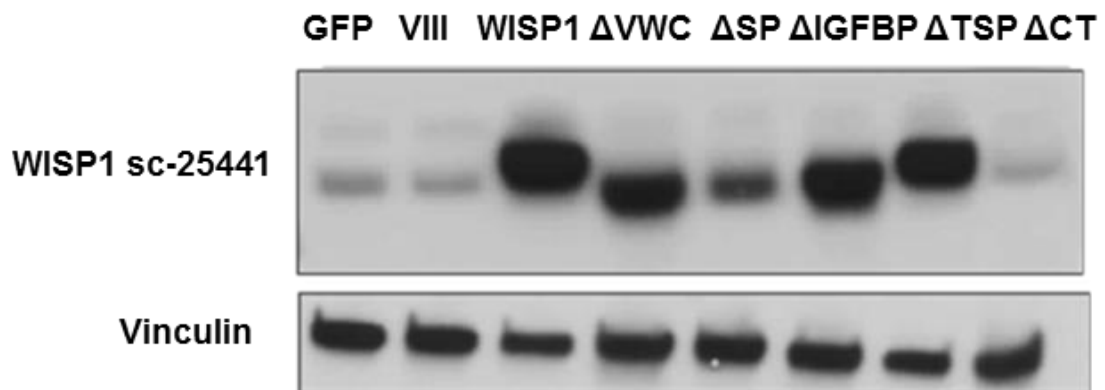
Immunoblots from lysates of U87MG cells expressing each truncated form and the controls (GFP, EGFRvIII, WISP1). Two different antibodies were used since the Δ CT WISP1 is not picked up by the antibody that recognizes an epitope from amino acids 311-367 (sc-25441) while the Δ VWC WISP1 is not picked up by the antibody that recognizes an epitope from amino acids 135-230 (ab155654). An immunoblot membrane using the same antibody against WISP1 used for the ELISA experiments (1627-WS) confirms that the antibody recognizes all the truncated forms except for Δ CT WISP1.
